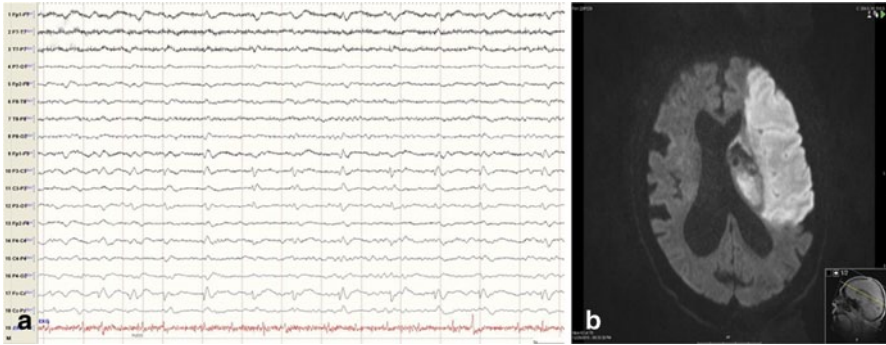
A patient with late poststroke seizures; EEG (a) shows seizure pattern in left fronto-central region, onset at C3–F3>F7–Fp1. Onset consisted of rhythmic alpha activity at F3–C3, then involved Fp1–F7, to evolve into rhythmic theta, then sharply contoured delta; seizure lasted 30–60 s. This patient suffered 18 seizures over 9 h. MRI (b) shows a focal encephalomalacia in the left posterior temporal and parietal lobes compatible with remote ischemic infarction
